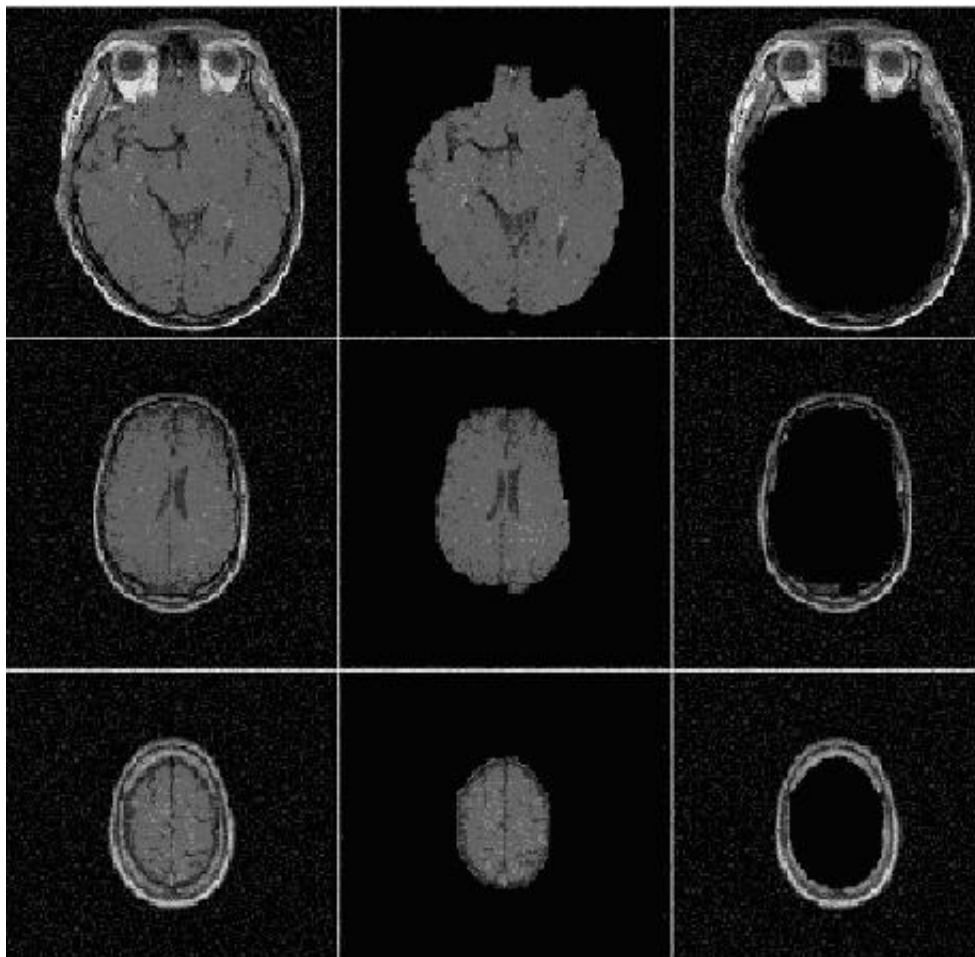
Left to right: original whole-head MR image; brain parts extracted; non-brain parts.
